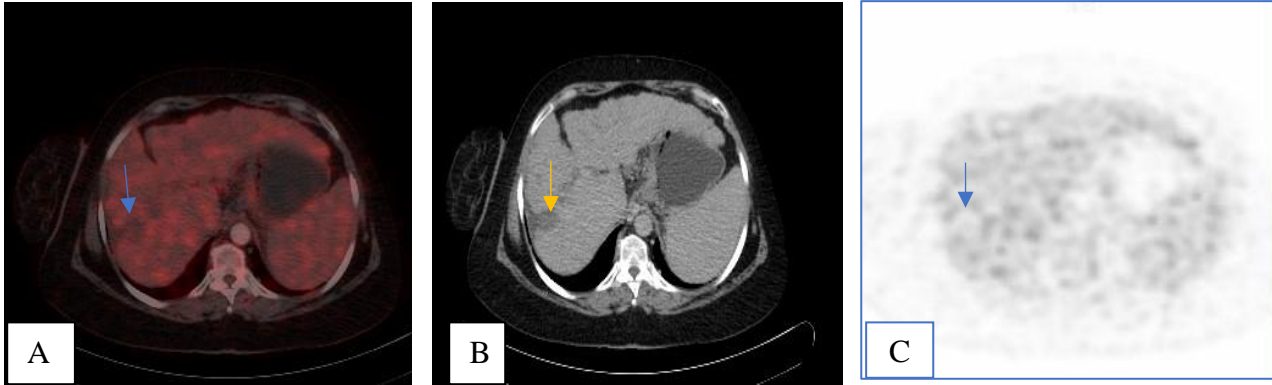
(A) Female patient aged 56 years, with liver HCC had radiofrequency, preparing for liver transplant and referred to PET/CT 1 month after RFA. (A, B & C) Axial PET/CT, CT & PET images shows photopenic area (blue arrow) related to the site of previously ablated sub-capsular focal lesion at segment VII with no contrast enhancement (yellow arrow) with retraction of overlying capsule denoting good ablation with no residual tumoral activity confirmed by decreased level of alfa fetoprotein (25 ng/ml).
